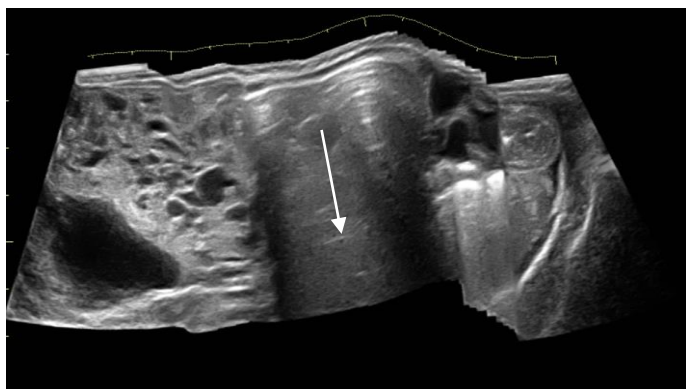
Panoramic sonogram of the post-natal child showing the relationship of the lesion to the rest of bowel
